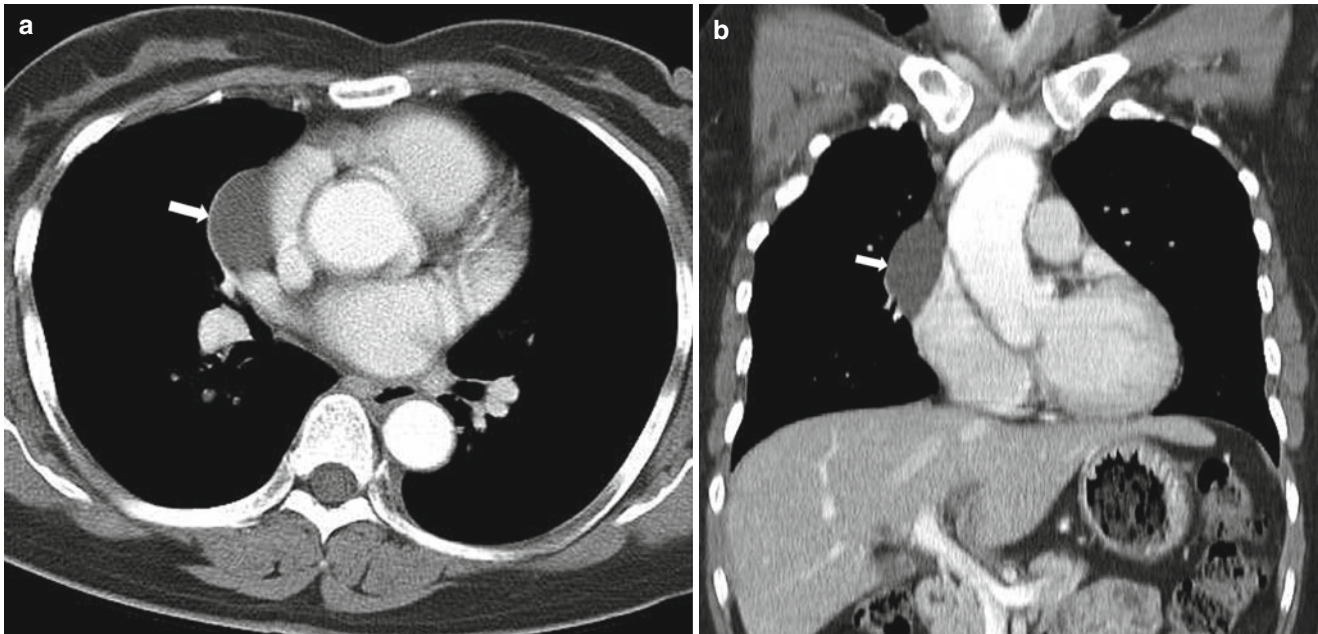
Pericardial cyst. (a, b) Axial and coronal images of chest CT show lenticular cystic mass (*arrow*) without perceptible thickened wall at right upper cardiac border
